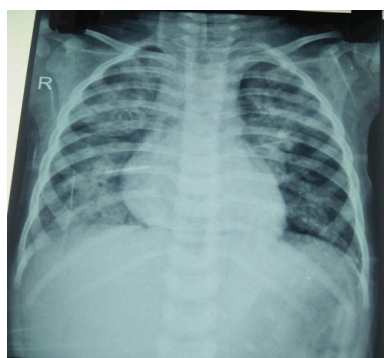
Chest x-ray revealed military pattern
